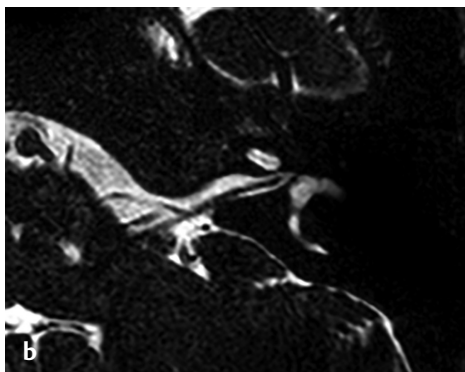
MRI CISS/FIESTA sequence, (a) oblique sagittal images at fundus of internal acoustic canal and (b) axial sections show absent cochlear nerve.
